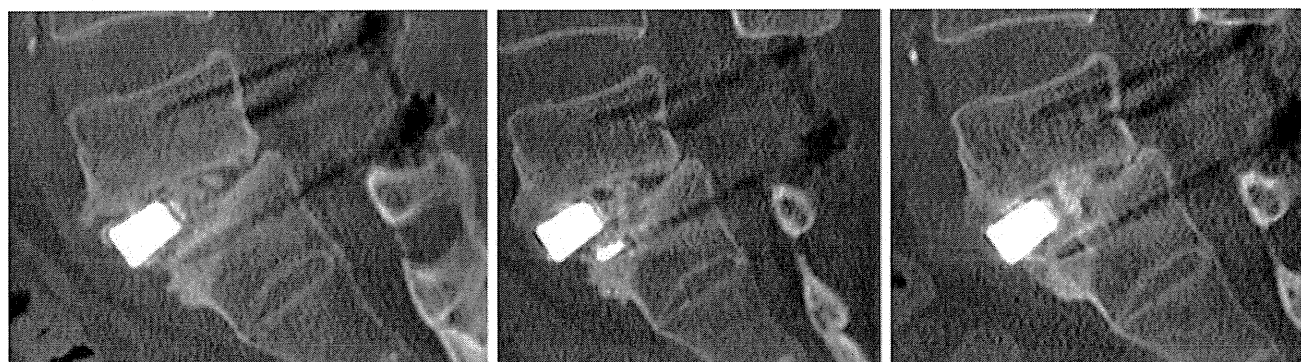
Sagittal multidetector-row computed tomography (MDCT) images taken immediately postoperatively and at 3 and 12 months for Case 5. The immediate postoperative image (*left*) shows an apparent gap between the porous titanium metal and vertebral bone. The
